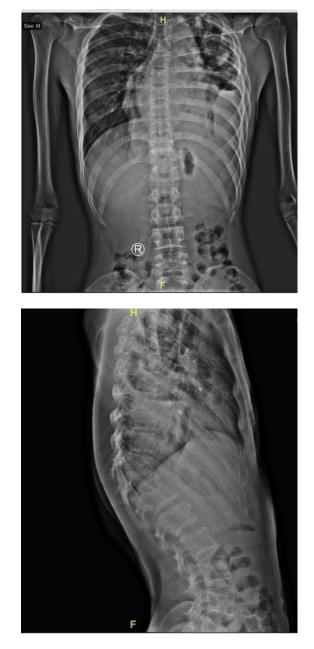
Thoracolumbosacral X-ray, Anteroposterior (A), Lateral (B).
